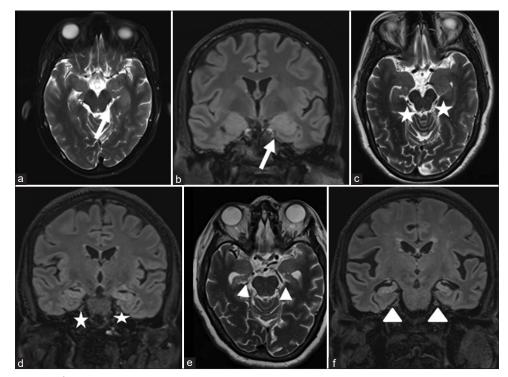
MRI Brain (a) axial T2 and (b) coronal FLAIR image shows mildly bulky left hippocampus and amygdala with hyperintense signal (arrow) (c) axial T2 and (d) coronal FLAIR image shows bilateral hippocampal atrophy with FLAIR hyperintense signal (star) (e and f) bilateral hippocampal atrophy with FLAIR hyperintense signal (arrowhead) *Abbreviations:* EEG = long-term video electroencephalography, FBCDS = faciobrachial dystonic seizures, MRI = magnetic resonance imaging, FLAIR = fluid-attenuated inversion recovery
